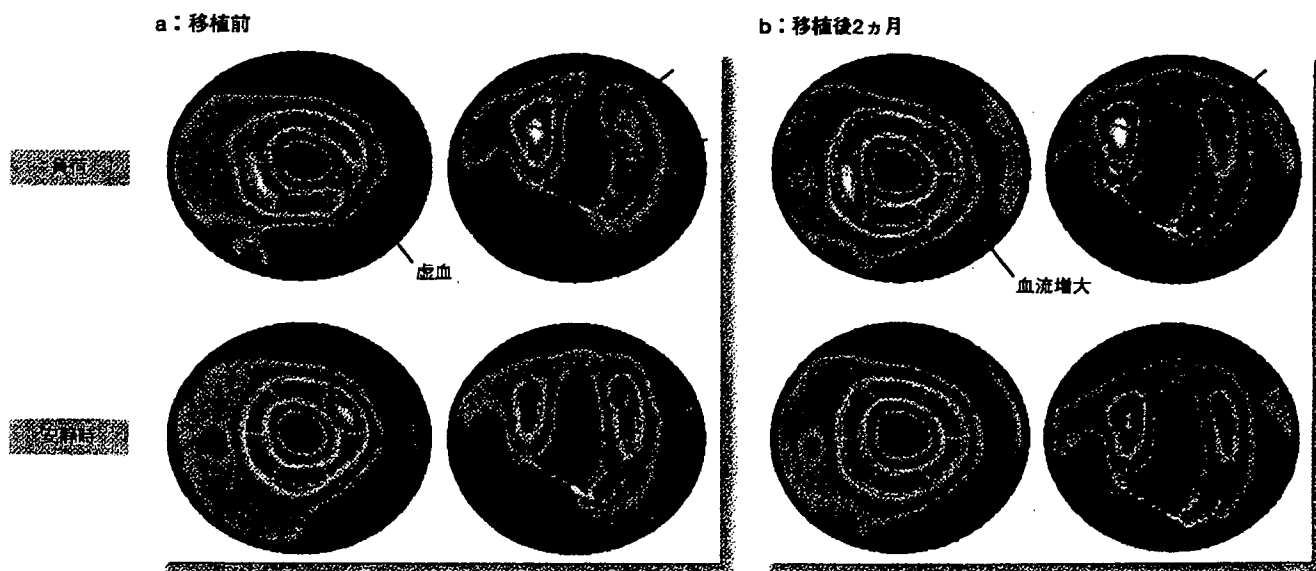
SPECT-sestamibi心筋シンチによる狭心症症例への骨髄単核球移植効果の評価
